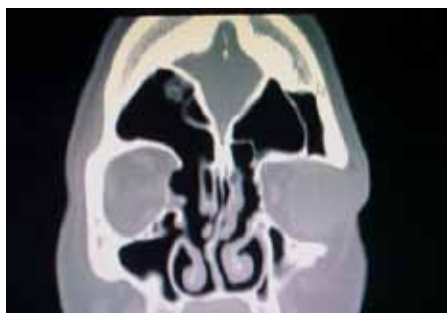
Sinus CT 4 years after surgery
